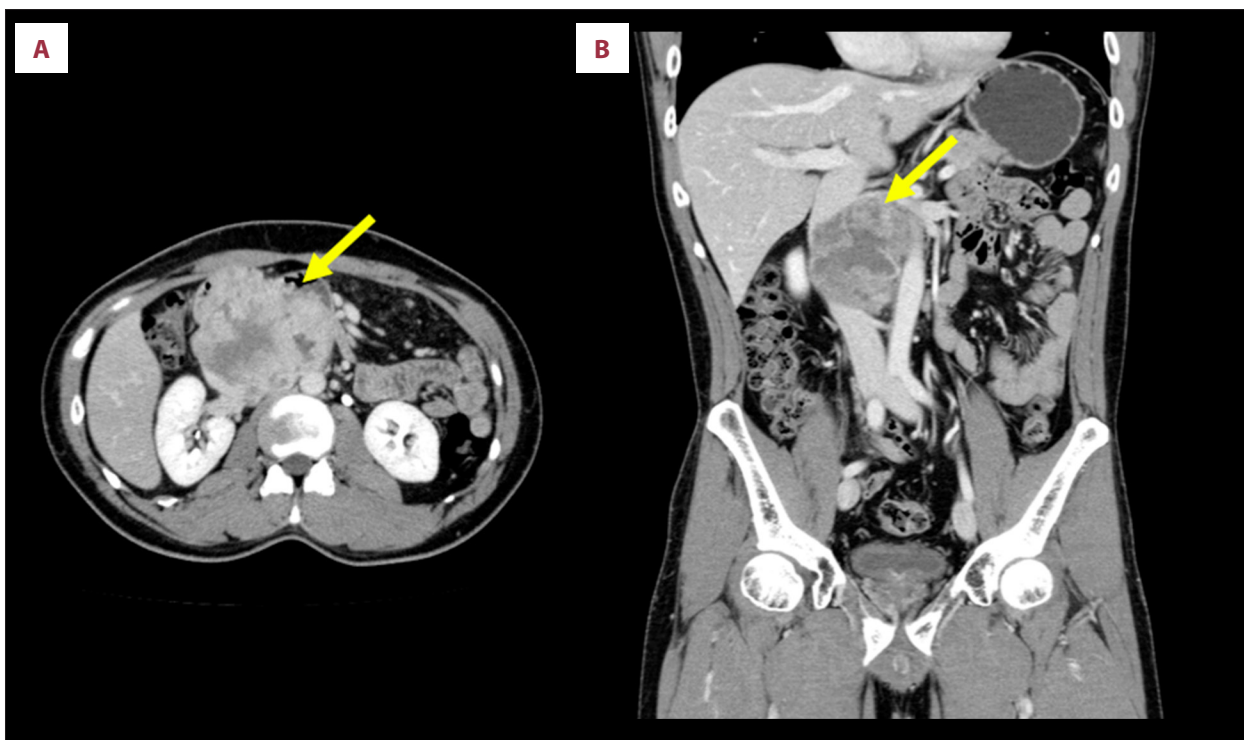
(A, B) Contrast-enhanced computed tomographic scans demonstrating a heterogeneous mass in the infrahepatic inferior vena cava (yellow arrows).
